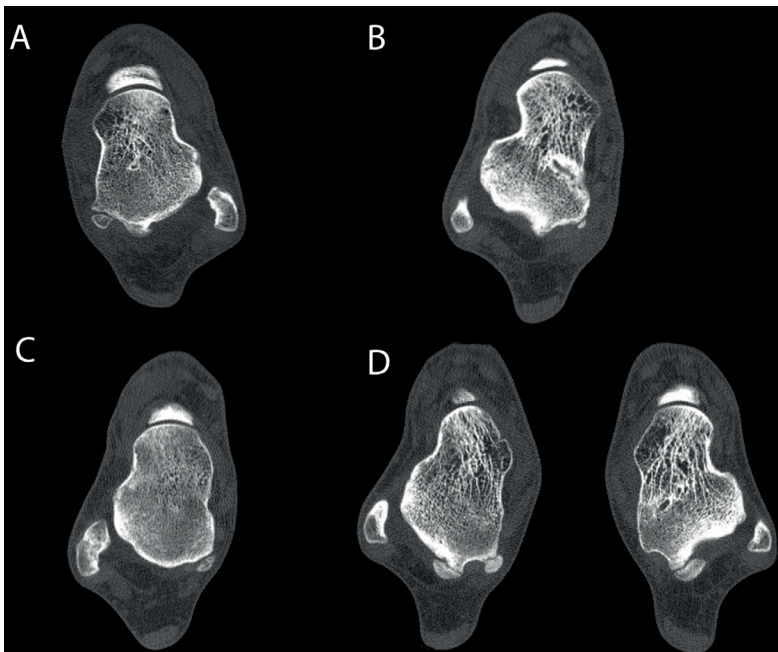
Medial tubercle fractures on CT imaging. A. Large fragment. B. Small avulsion. C. Image of an asymptomatic nonunion of avulsion fragment. D. Image of patient with bilateral os trigonum and medial tubercle fracture of his right ankle.
